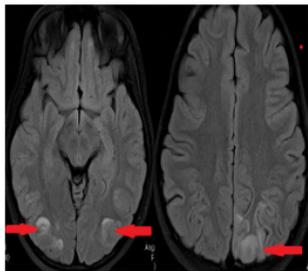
Typical PRES – Axial FLAIR images showing hyperintense signal involving bilateral parieto-occipital lobe (Red arrow).
